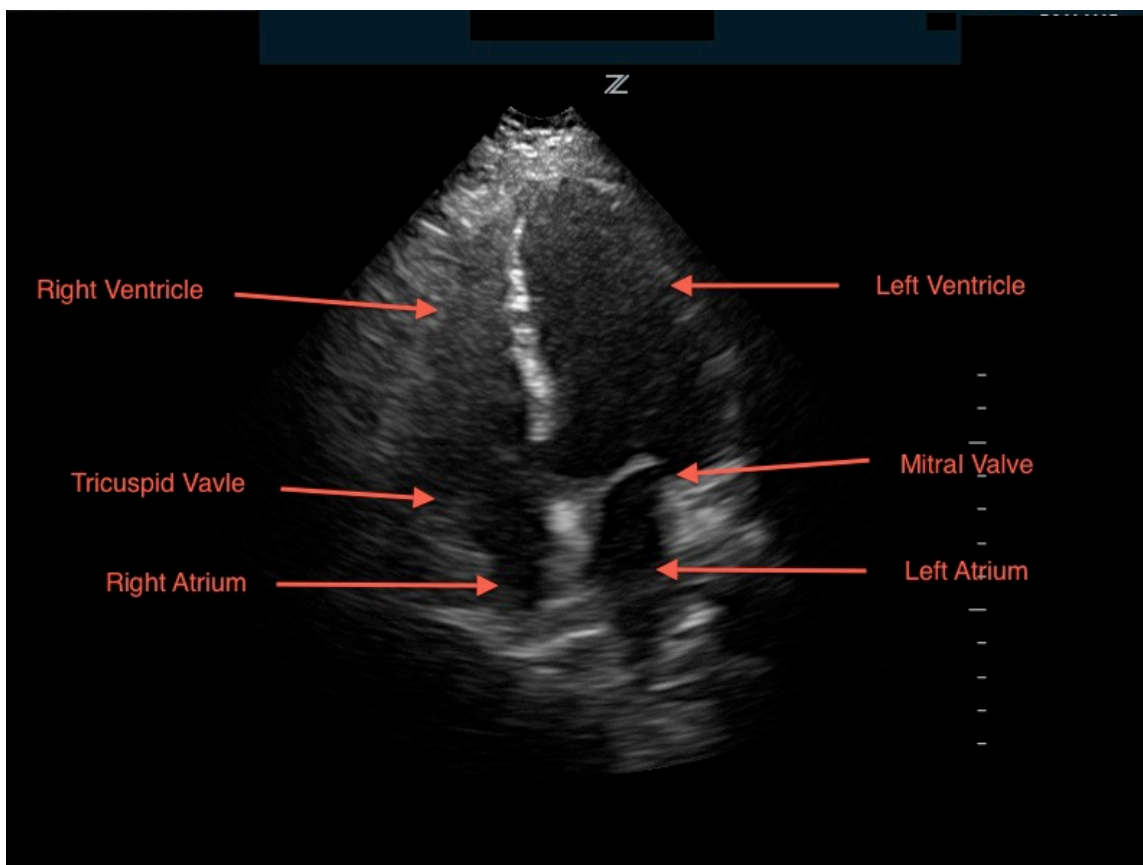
Cardiac Apical 4 Chamber
